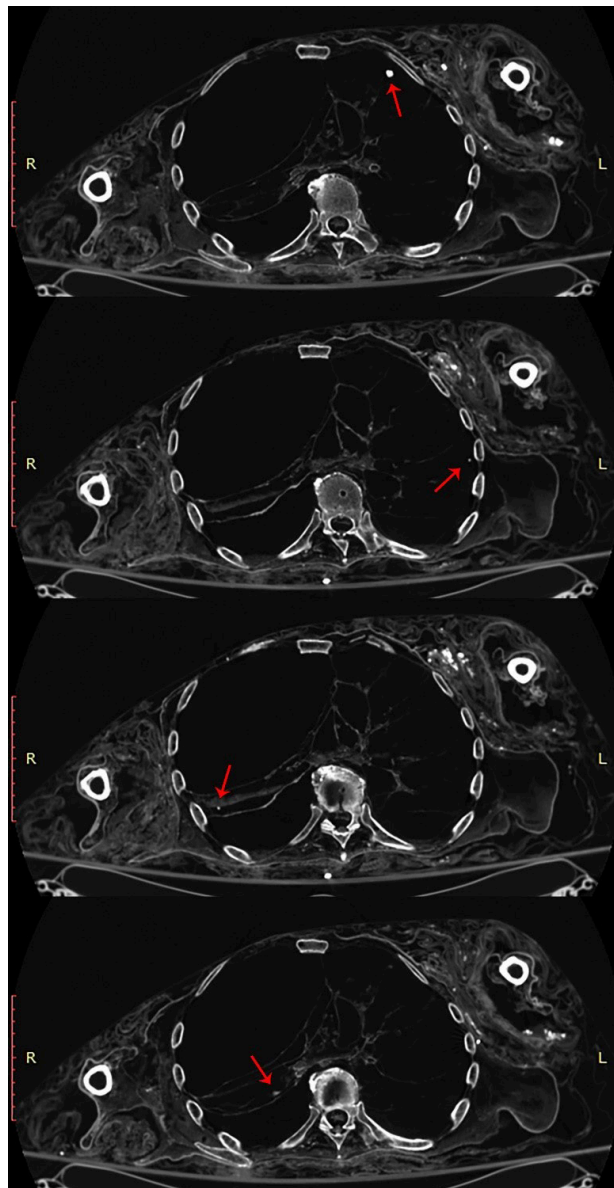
CT scans of the thorax showing pleural adhesions and lung nodules (arrows).
